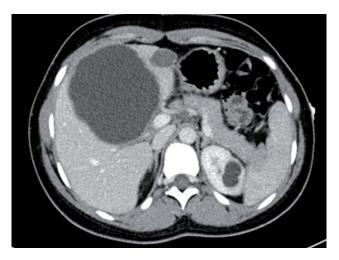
Contrast enhanced abdominal Computed Tomography showing two hypodense formations compatible with hydatid cysts of the IV-V e III hepatic segments.
